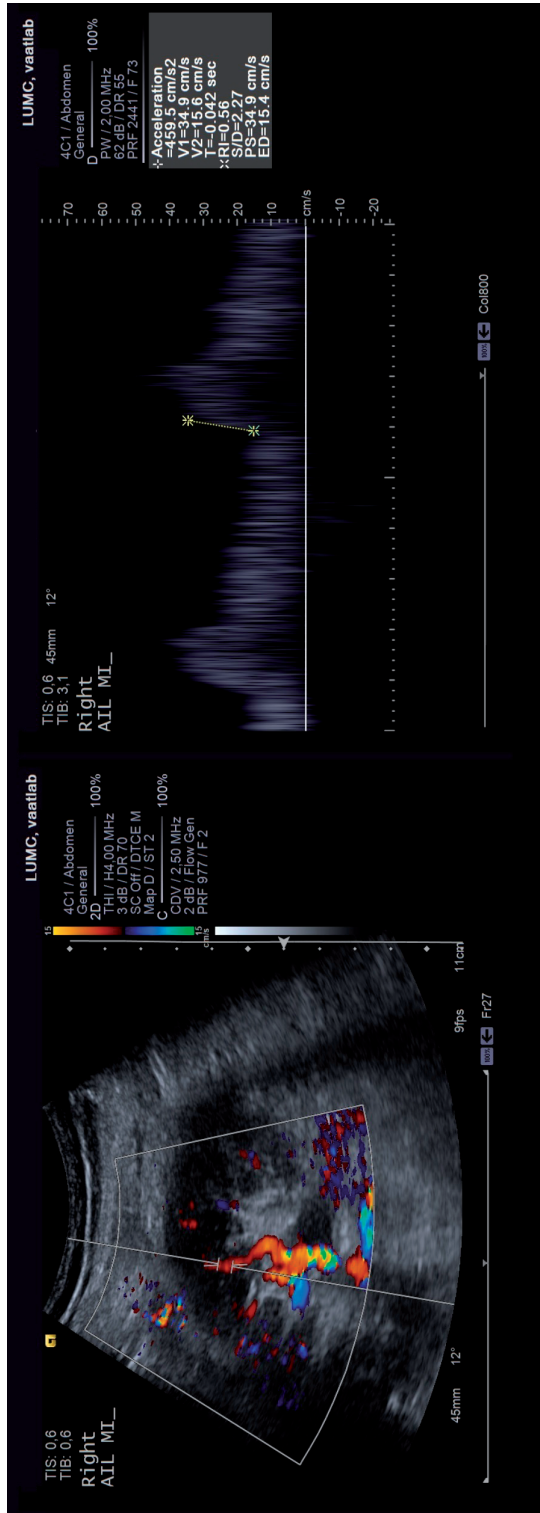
The RI (0.56) and ACCmax (0.46 m/s<sup>2</sup>) were obtained by intrarenal Doppler ultrasonography. For measuring ACCmax, the angle of insonation will be close to null because the course of the interlobar artery is mostly perpendicular to the surface of the kidney. In this example, the angle of insonation is 12°.
